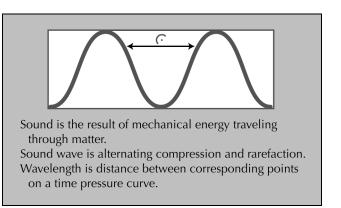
A description of the tenets of ultrasonography.
